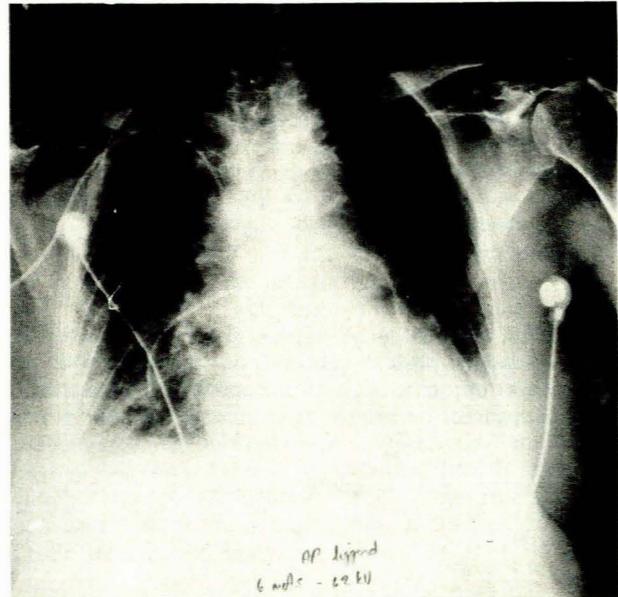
Chest radiograph showing cardiomegaly, pulmonary congestion, possible pulmonary plethora and small pleural effusions.
